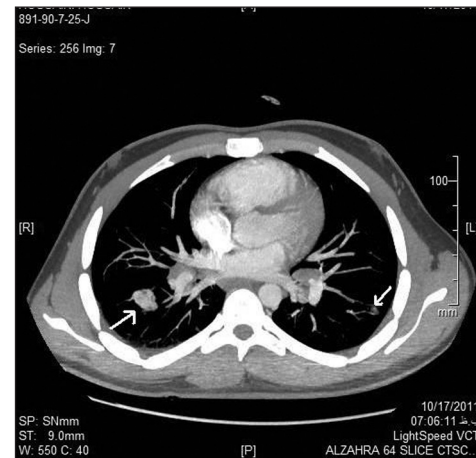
Thoracic CT shows AVM in Superior segment of both lower lobes (arrows)
